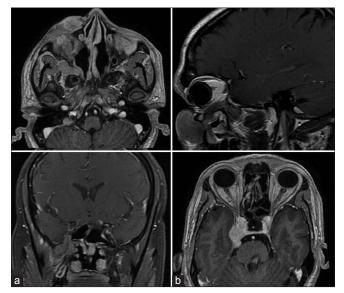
Fat-suppressed contrast-enhanced T1-weighted axial (a), sagittal (b), coronal (c), and axial (d) images show homogenous enhancement of the lesion
